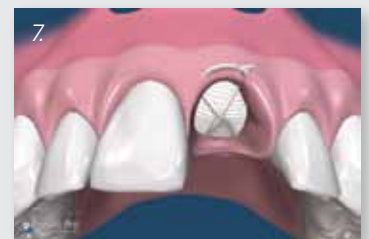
The membrane is removed, non-surgically, in 21 - 28 days. With intact sockets, the membrane may be removed as early as 3 weeks. Studies have shown that by 21-28 days there is a dense, vascular connective tissue matrix in the socket and early osteogenesis is observed in the apical 2/3 of the socket. Sockets with missing walls may benefit from a longer time frame. Topical anesthetic is applied, and then the membrane is grasped with a tissue forcep and simply removed with a gentle tug.
